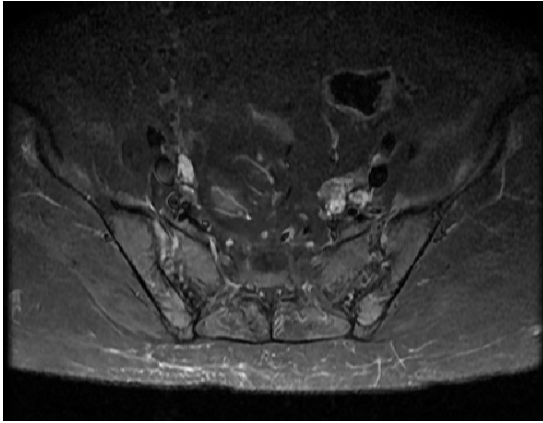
MRI of the pelvis showing bilateral sacroiliitis.
